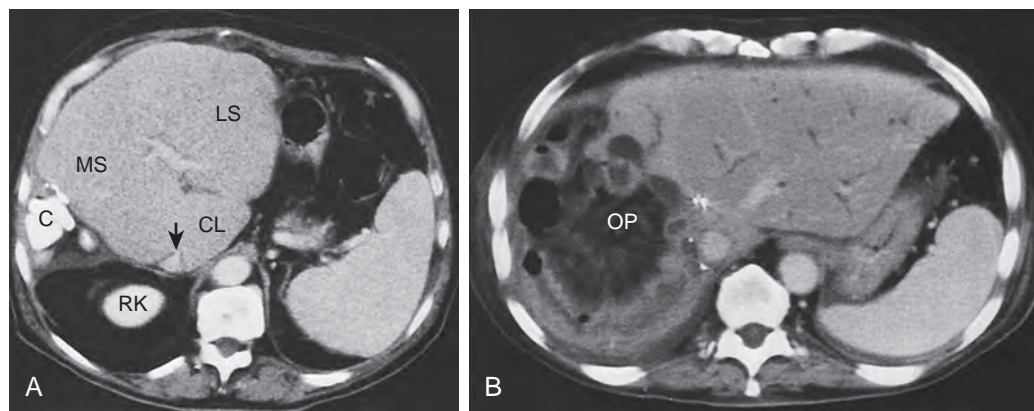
Postoperative liver: CT findings. A. Typical CT appearance after right hepatic lobectomy. There is hypertrophy of the medial segment (MS) and lateral segment (LS) of the left lobe and caudate lobe (CL). Elevation of the right kidney (RK), posterior displacement of the inferior vena cava (arrow), and migration of colon (C) into the hepatic fossa are seen. B. This patient had a trisegmentectomy with construction of a greater omental pack (OP) along the lateral aspect of the remaining lateral segment of the lobe. The patient developed a recurrent tumor, accounting for the intrahepatic biliary dilation.
